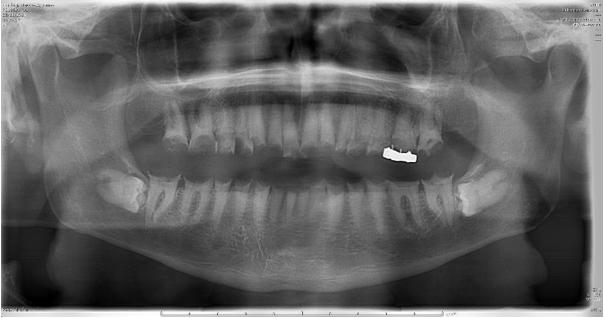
Orthopantomogram radiograph taken eight months after completion of radiotherapy showing severe tooth wear and caries affecting all erupted teeth
